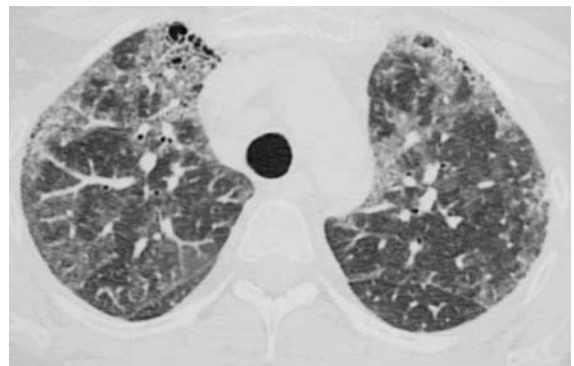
Rheumatoid arthritis in a 49-year-old woman. HRCT scan shows diffuse bilateral areas of patchy ground-glass opacities. Note small cyst (honeycombing) in the anterior part of both upper lobes. Open lung biopsy showed findings of mixed NSIP.
